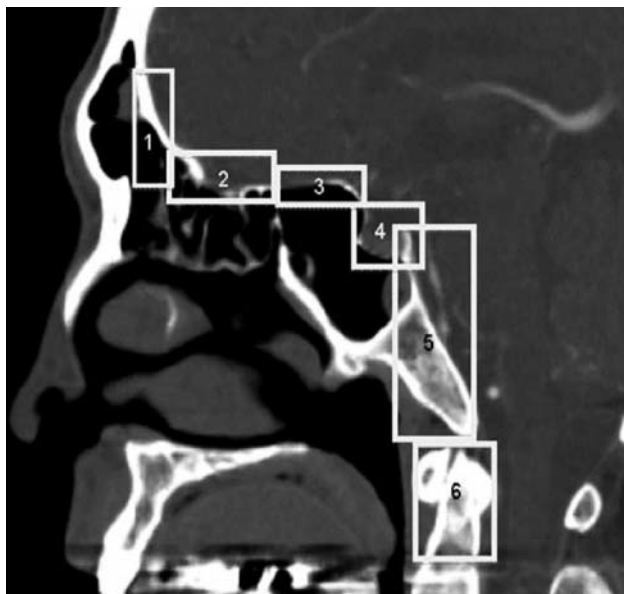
Lateral CT scan showing the best way to plan the surgical approach according to the localization of the disease.
